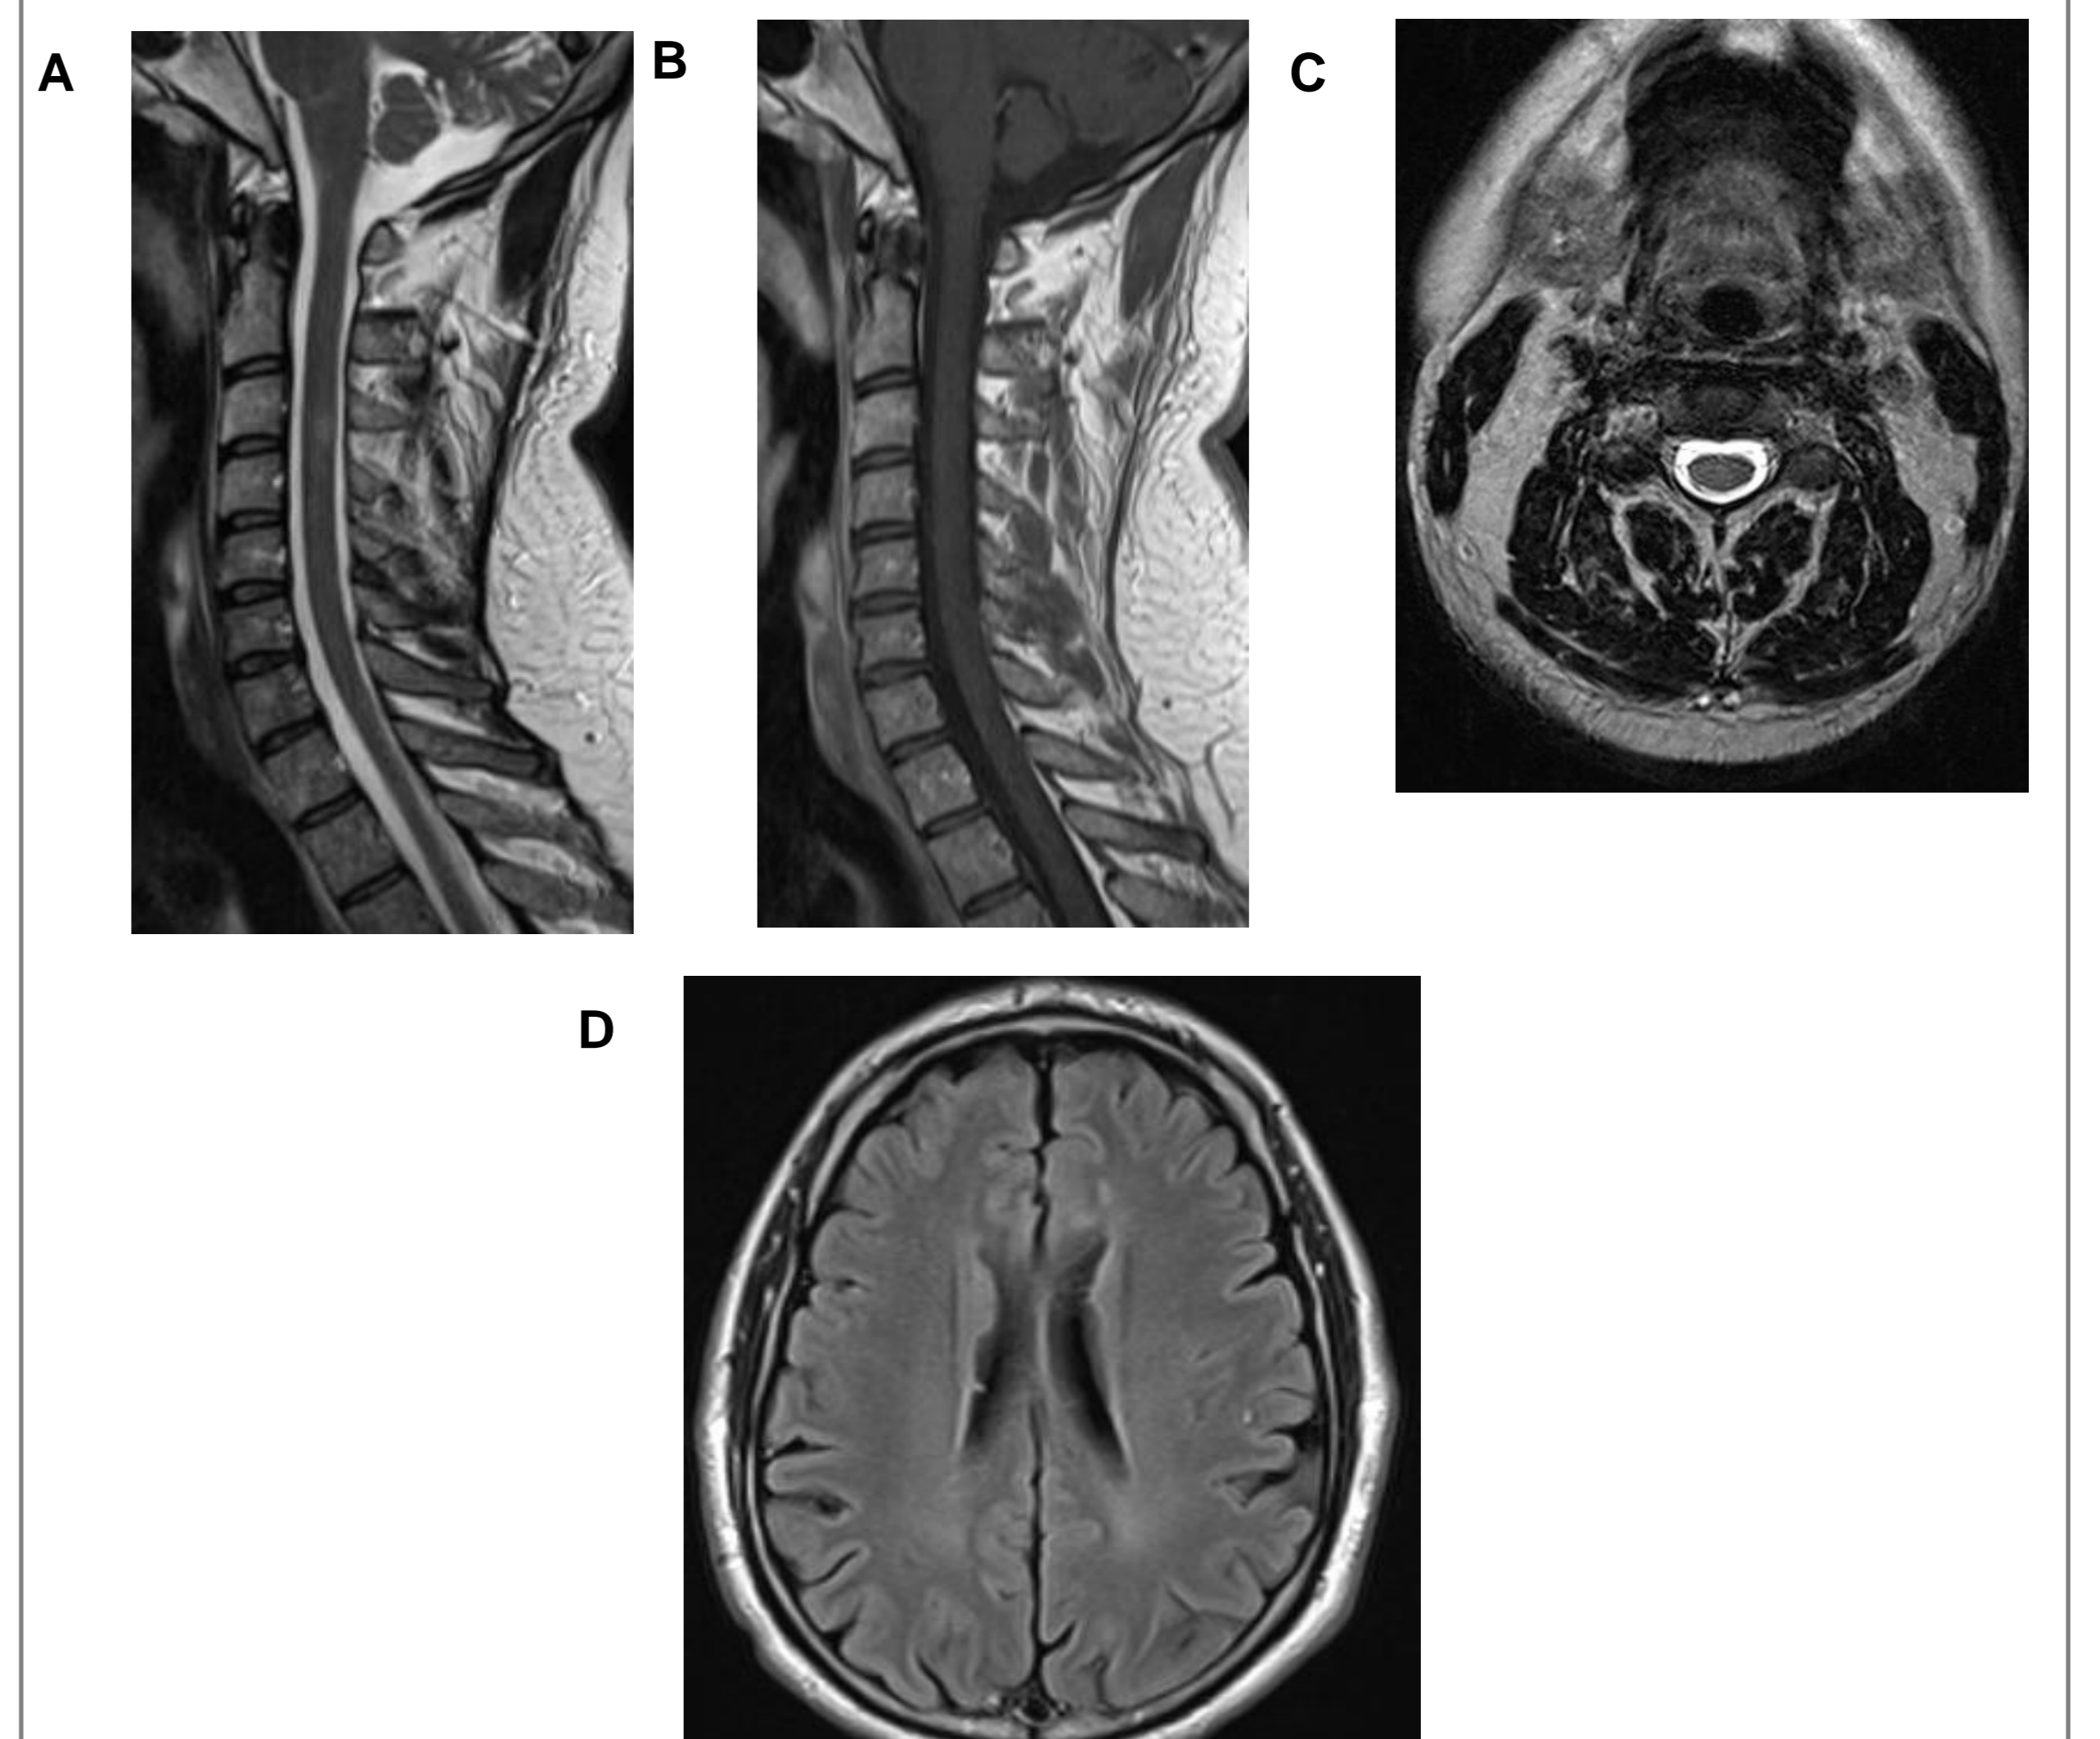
MRI at follow-up. Panel A: sagittal, T2 weighted spinal MRI. Panel B: sagittal, T1 weighted, Gd + spinal MRI. Panel C: axial, T2 weighted, spinal MRI. Panel D: axial FLAIR brain MRI
